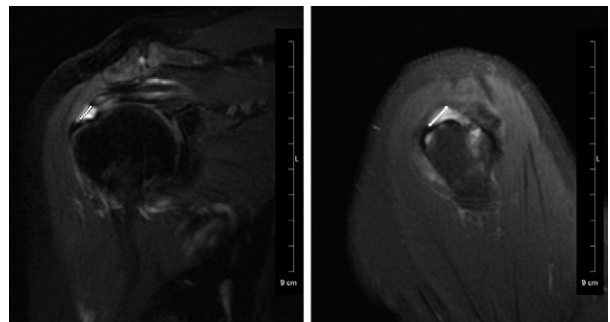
Clinical example of a type 1, crescent-shaped tear on MRI with maximum coronal length (left) less than maximum sagittal width (right).
